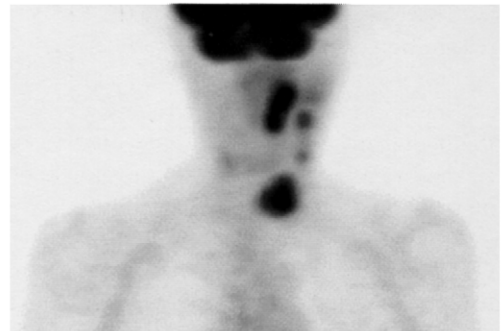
F18-FDG-PET scan of a 69 year old woman with squamous cell carcinoma of the left maxilla, infiltration of the left sinus maxillaris, left cervical lymph nodes, left supracerivical lymph node bulk.
